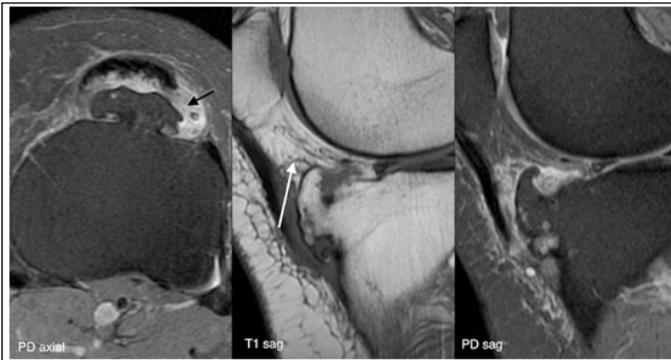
Radiological findings: Axial PD fat saturation, sagittal T1 and sagittal PD fat saturation MRI images (left, middle, and right).Osteochondroma is arising from the proximal tibia. Note how it grows toward the joint (white arrow), which is a rare finding. Connection to the tibia is through a wide stalk. Inflammatory changes in the adjacent Hoffa's fat pad suggest mechanical impingement (black arrow). No thickening of the cartilage cap >2cm is noted.
